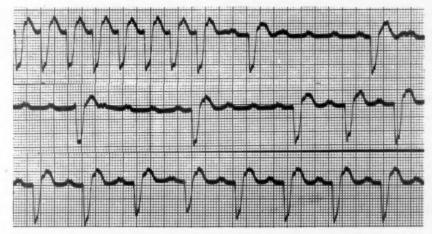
Continuous strip of atrial lead (V lead in the parasternal line, right third intercostal space) during left carotid sinus massage. Atrial tachycardia, rate 166 per minute, is evident when ventricular responses are blocked.
